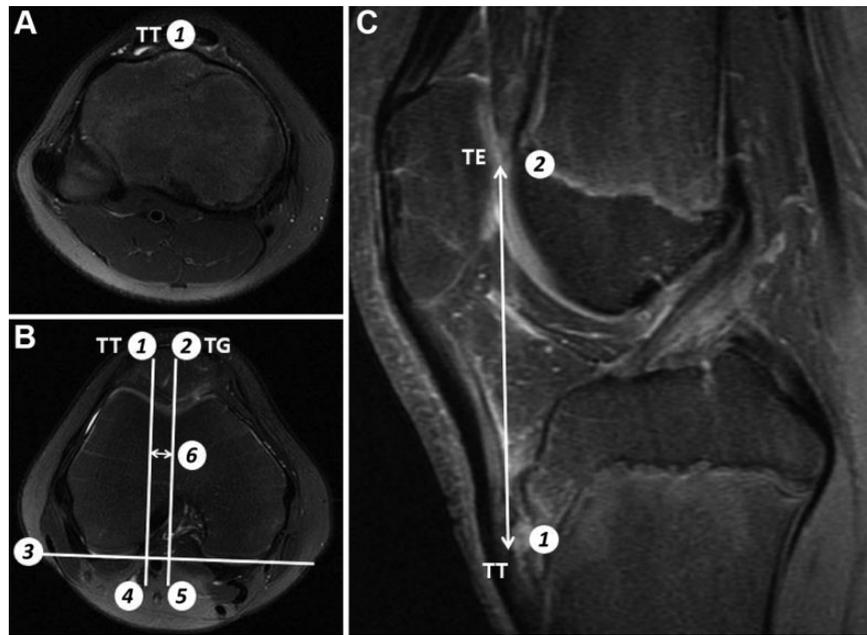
Measurement of the tibial tuberosity–trochlear groove (TT-TG) distance and TT-TG index. (A) The location of TT (1) was identified from the axial view of magnetic resonance imaging. (B) Next, a line was drawn between the deepest bony point of TG (2) and a superimposed perpendicular line (5) tangent to the bony borders of the posterior condyles (3), and a second line (4) was drawn parallel to the trochlear line through the most anterior portion of the tibial tubercle. The distance between these 2 parallel lines was the TT-TG distance (6). (C) The deepest point of the chondral trochlear entrance of the trochlear groove (TE) in the axial sequence was transferred to the sagittal T2-weighted sequence (2). The most proximal point of complete attachment of the patellar tendon to the tibial tubercle in the axial sequence was transferred to the sagittal sequences (1). The proximodistal distance between the height of these transferred points was measured in the sagittal plane (TT-TE distance, line 1-2). The TT-TG index was the cartilaginous tendon TT-TG distance divided by the TT-TE distance between the tibial tubercle and the proximal chondral entrance of the trochlear groove.
